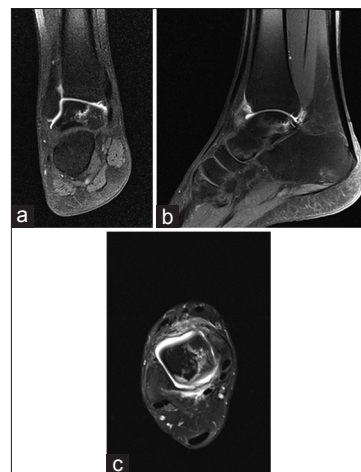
Arthro-magnetic resonance images at follow-up (at 6 months postoperatively) showing signs of avascular necrosis of the lateral part of the talus with signs of revascularization (a) coronal view (b) sagittal view (c) axial view
